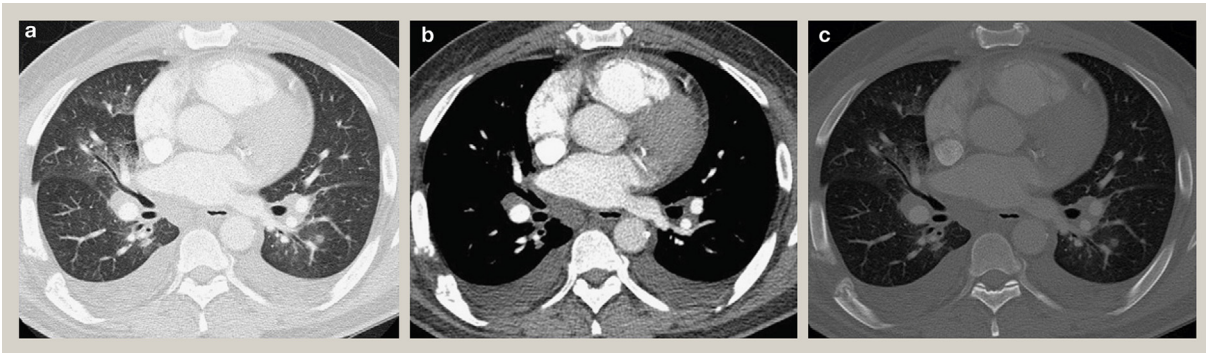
Three CT images from a single acquisition, photographed at identical anatomical levels but displayed on three different window settings: (a) lung, (b) soft tissue, (c) bone.
